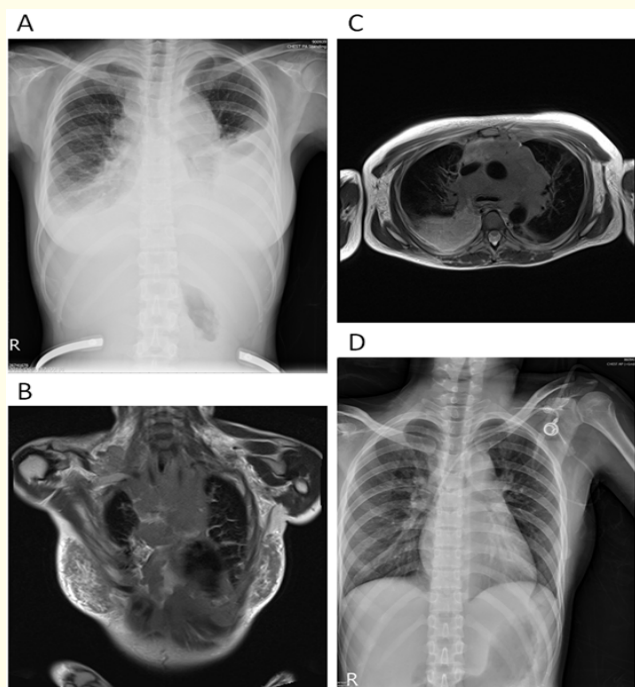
Image at diagnosis and after cytotoxic therapy. (A) Chest X ray at diagnosis. (B) Sagittal section of magnetic resonance image at diagnosis. (C) Coronal section of magnetic resonance image at diagnosis. (D) Chest X ray after the first cycle of chemotherapy
